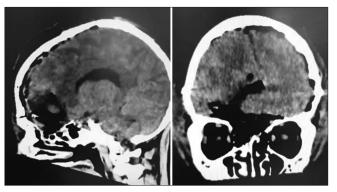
First-day postoperative computed tomography scan showing gross total resection of the tumor.
